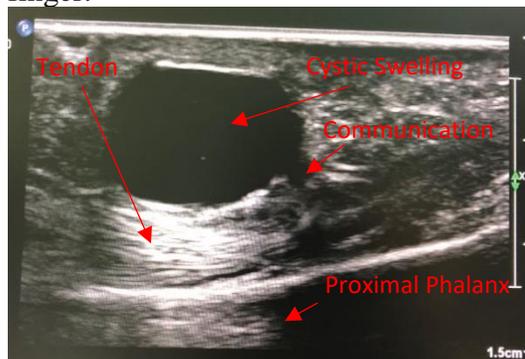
Ultrasound showing cystic swelling communicating with tendon sheath.
